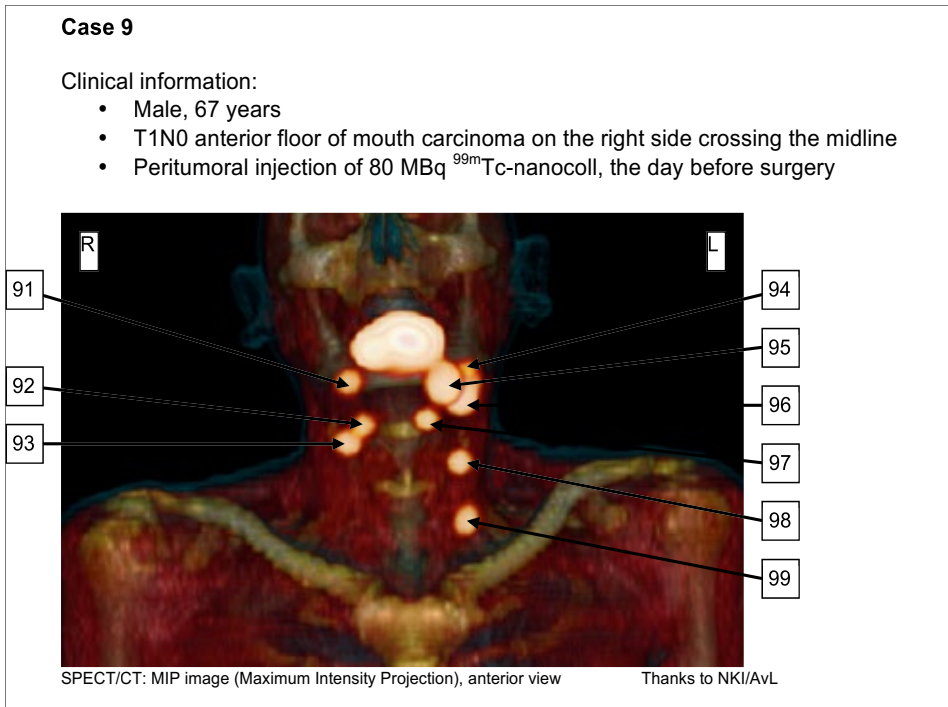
Case 9 with SPECT/CT
